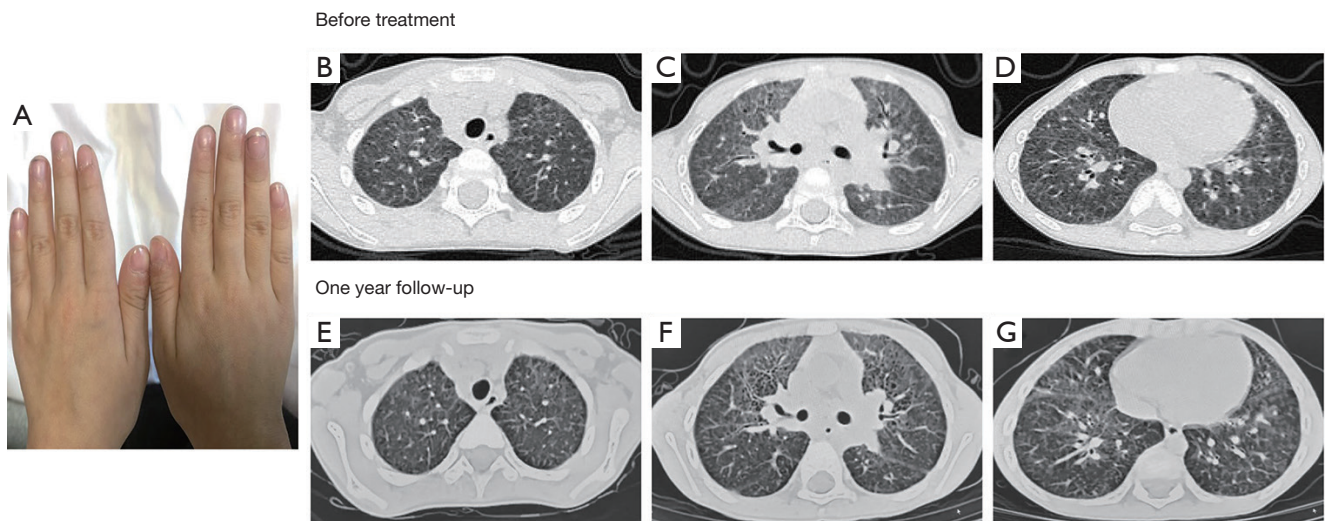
Clinical manifestations and chest image of case 3. (A) Clubbing fingers of case 3. (B-G) Chest high-resolution computed tomography scan of case 3. Diffused ground-glass and fine reticular opacities in case 3.
